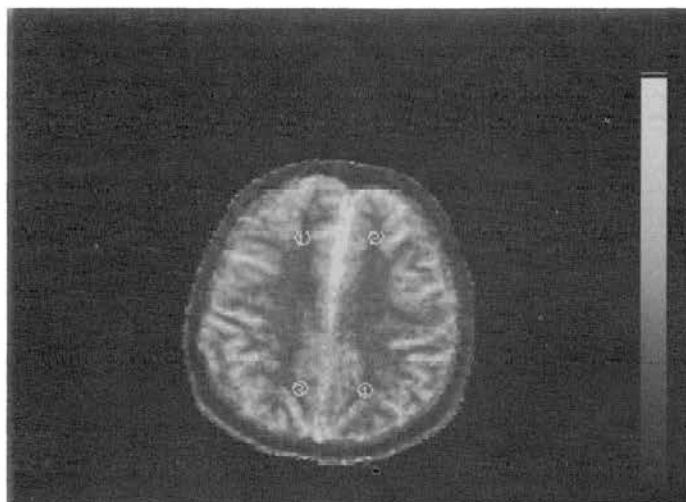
An example of an MRI scan in a patient indicating region of interest marker.
